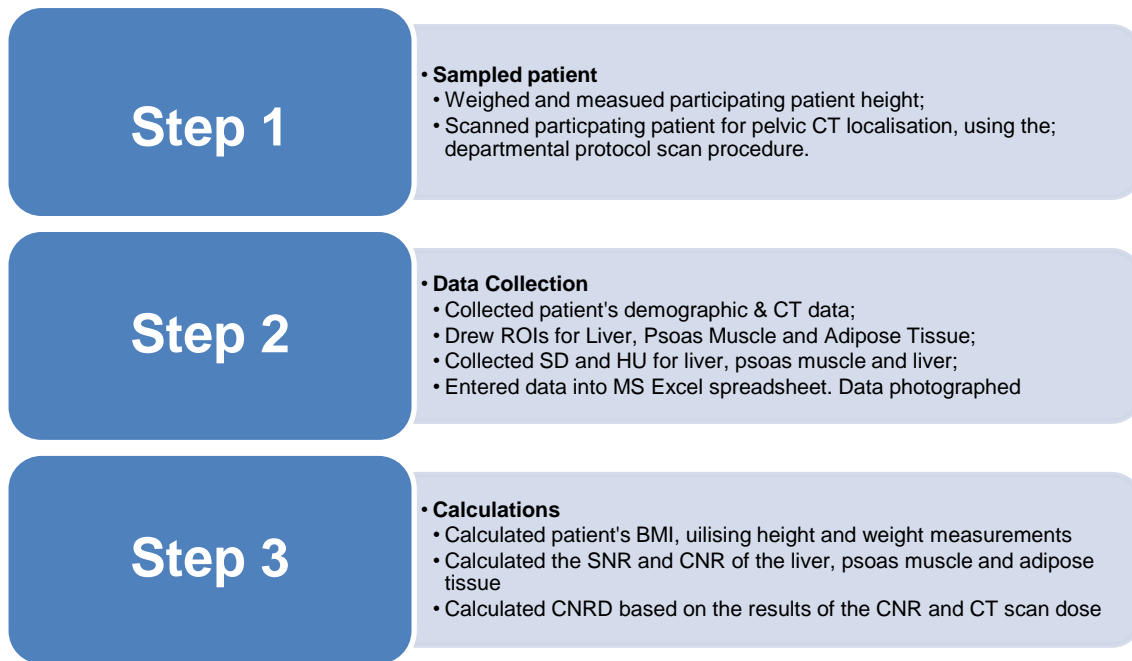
Research process image quality for patients CT scans.
